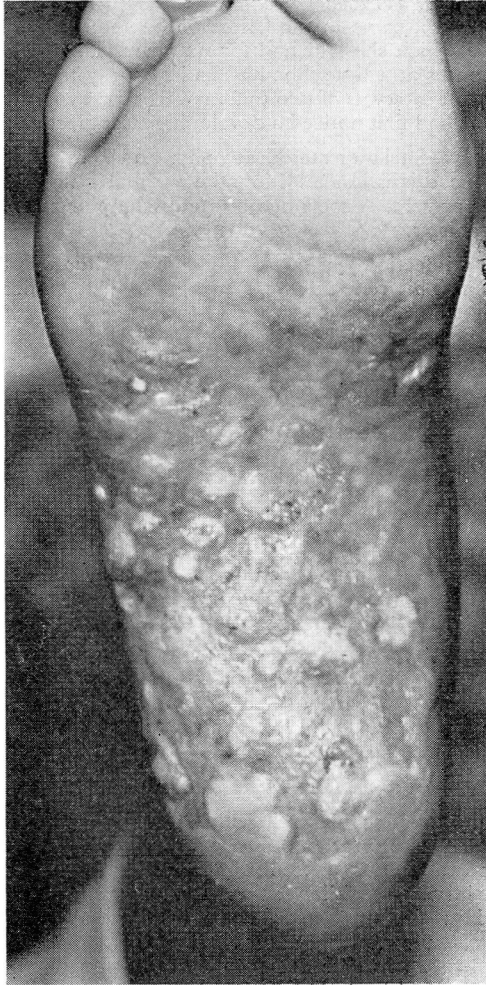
Radiodermatitis of sole following roentgen therapy for epidermophytosis. Case 5.
